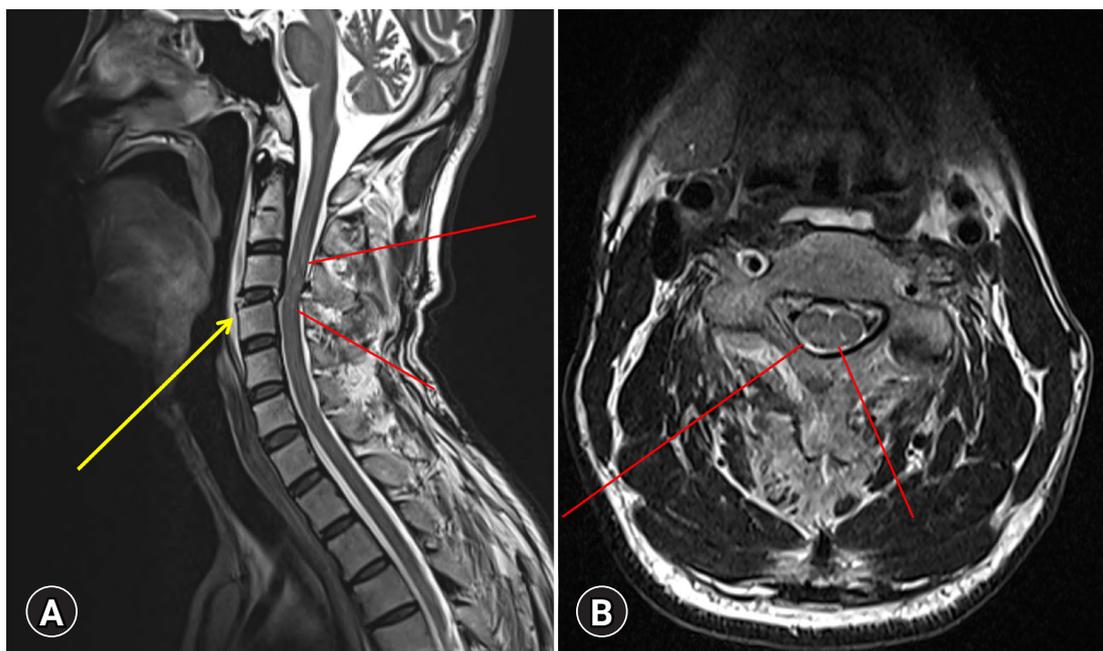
Cervical spine magnetic resonance image. Magnetic resonance image scan performed when the patient was admitted to the hospital revealed C3/4 dislocation, highly suspicious anterior discoligamentous complex rupture at C3–4, (A) prevertebral soft tissue hematoma at the C2–5 level (yellow arrow), and (A, B) spinal cord contusion with hematoma at the C3–4 level (red lines).
